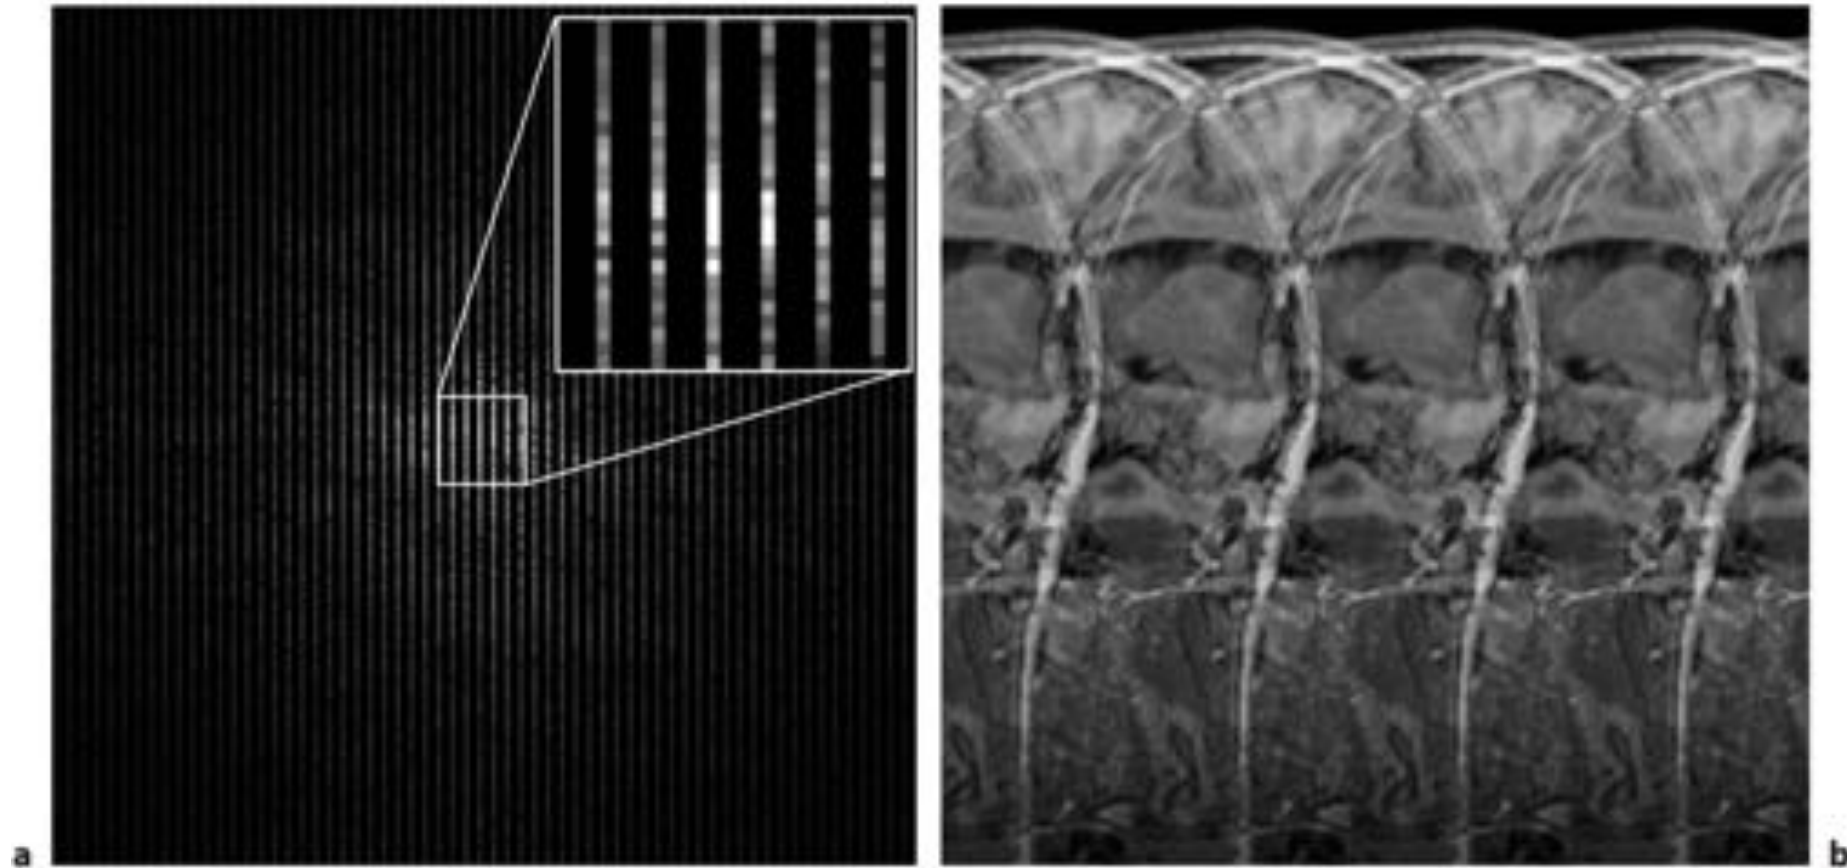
a Raw data after removing three of four neighboring lines and b corresponding reconstructed MR image. The effective field of view of the image is reduced to 25%, resulting in severe aliasing artefacts in anterior-posterior direction.
